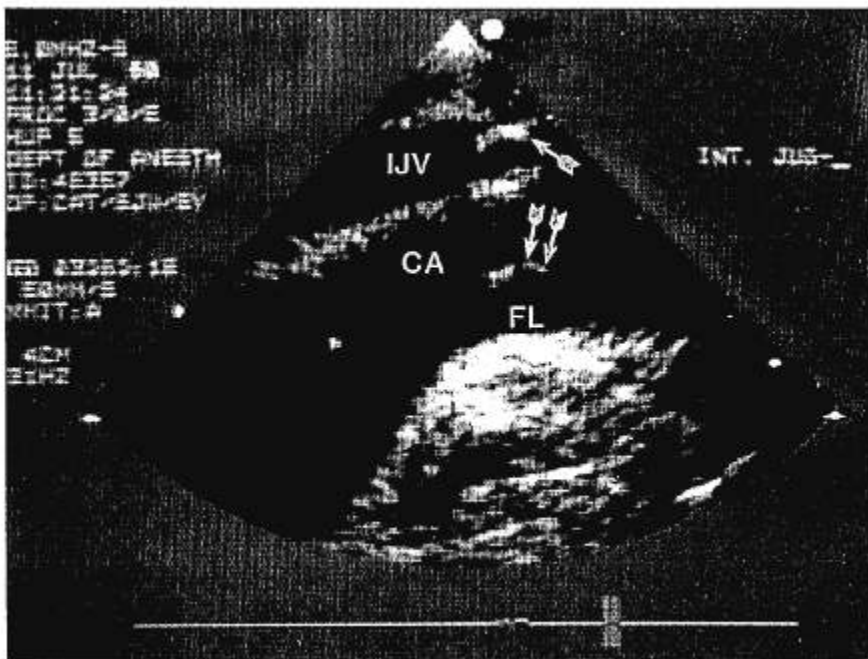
Two-dimensional ultrasound image of the right internal jugular vein (IJV) and carotid artery (CA). Single arrow indicates catheter entering IJV. Double arrow indicates intimal flap (FL) from aortic dissection extending into CA. Long axis view: top is anterior; right is cephalad.
